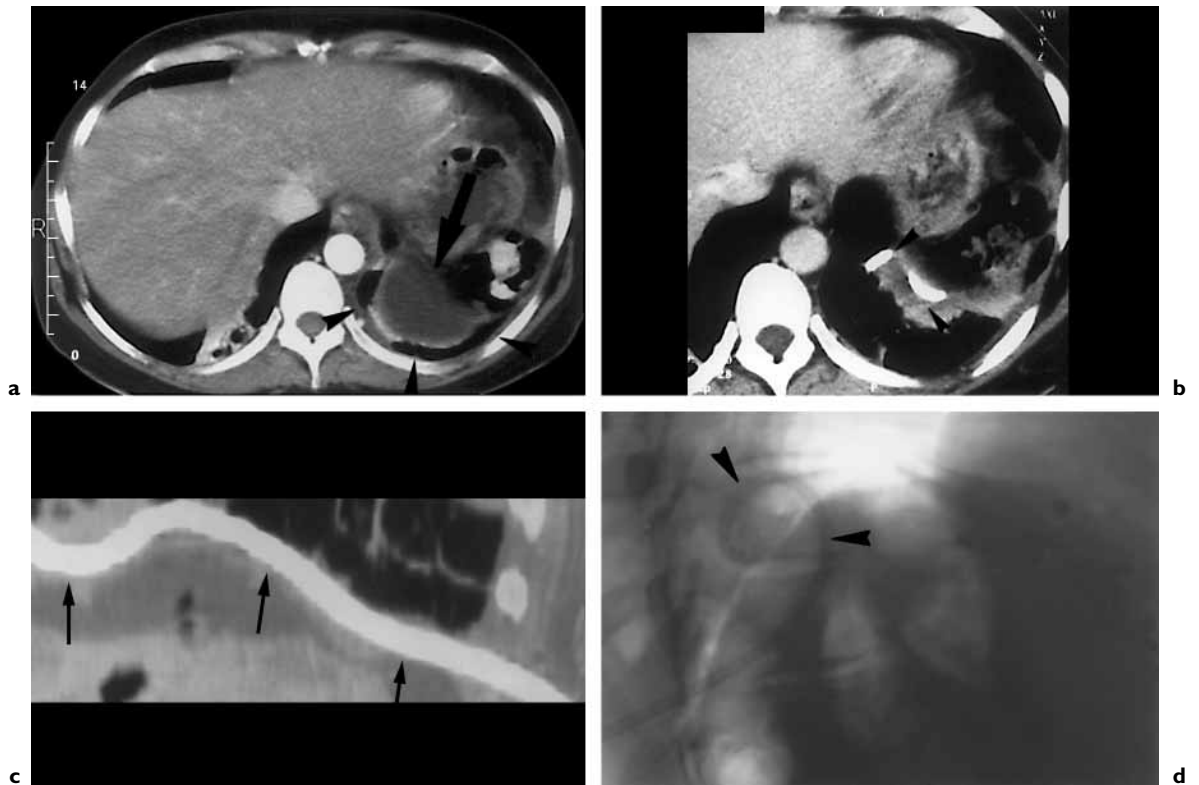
Percutaneous drainage of a loculated empyema by an extrapleural pathway. a CT shows a left basal loculated empyema (arrow) following resection of the spleen, left adrenal and left kidney for invasive adrenal cancer. Note that the collection is surrounded by pulmonary parenchyma (arrowheads) preventing puncture in an axial plane. b A 9F pigtail catheter was inserted under combined CT and fluoroscopic guidance with an oblique extrapleural approach along the diaphragm. The curled pigtail tip of the catheter is documented inside the collapsed cavity (arrowheads). c Curved multiplanar reformatting along the catheter pathway (arrows) demonstrates its extrapleural position and the absence of lung injury. d Fluoroscopic view shows the extremity of the catheter coiling in the empyema (arrowheads).
